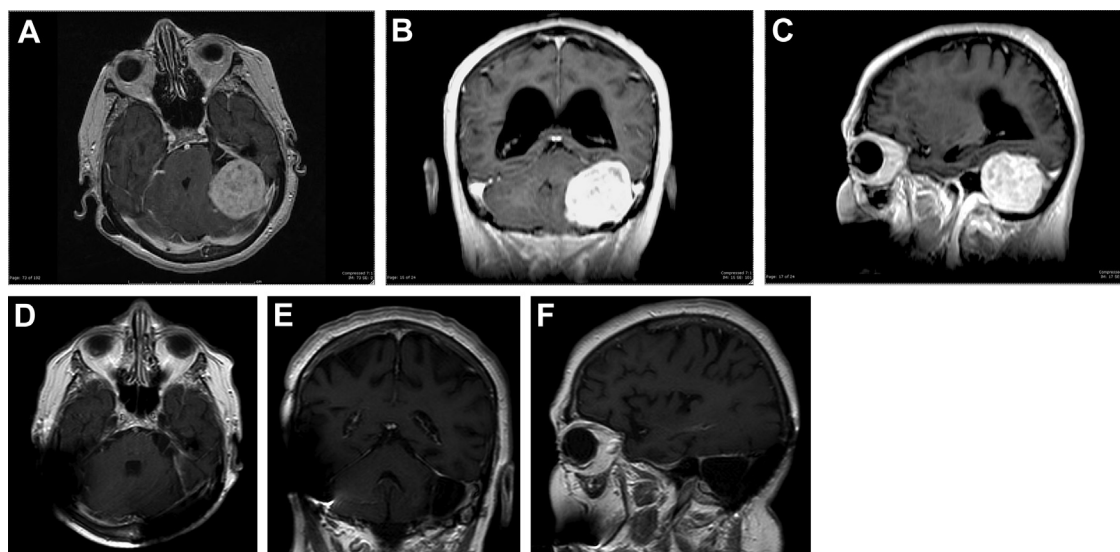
Neuroimaging. (A–C) Preoperative magnetic resonance imaging T1-weighted sequences with gadolinium (axial, coronal, and sagittal views) revealed a $4.7 \times 4.3 \times 4.5$ cm posterior fossa tumor in the left cerebellopontine angle with marked mass effect and moderate hydrocephalus. The tumor demonstrates heterogeneous but prominent enhancement. (D–F) Follow-up magnetic resonance imaging T1-weighted
